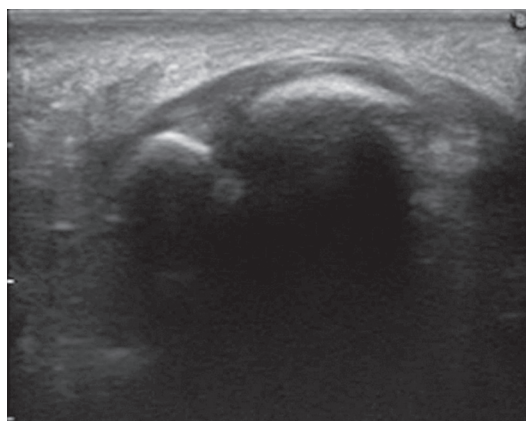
Sonographic scan showing plantar plate tear graded G1 with the Hamilton-Thompson test
